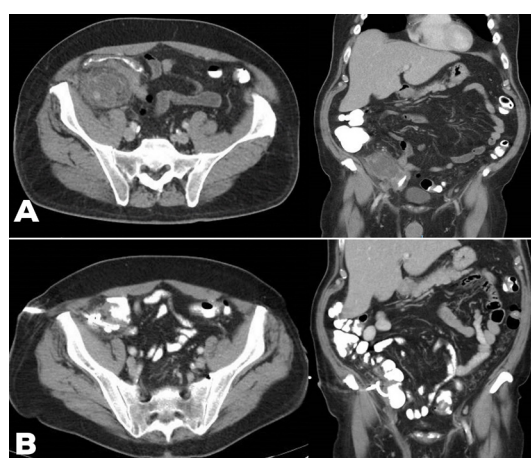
(A) CT of the abdomen and pelvis demonstrating complex, phlegmonous collection in the right lower quadrant measuring $6.5\times 4\times 5\text{ cm}$ and associated reactive caecal wall thickening consistent with perforated appendicitis. (B) CT of the abdomen and pelvis with confirmed position of the drainage catheter; no significant residual collection and interval improvement in previously noted inflammatory changes.
